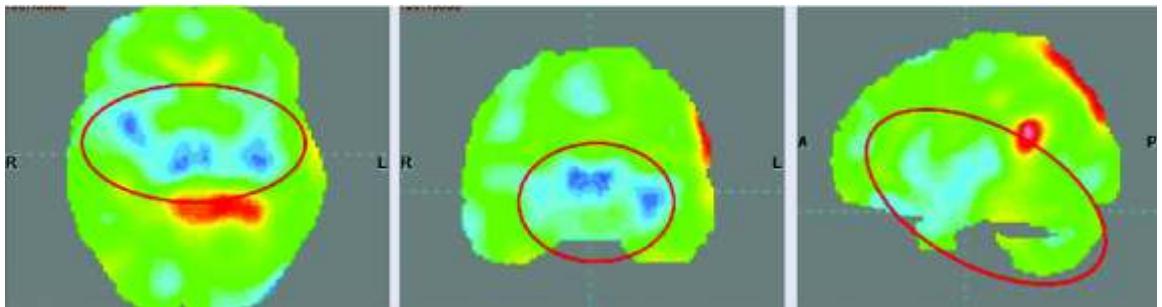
PET-CT scan 9 months after cellular transplantation showing increased metabolism in the regions of hippocampus, basal ganglia and cerebellum bilaterally as indicated by the circles
